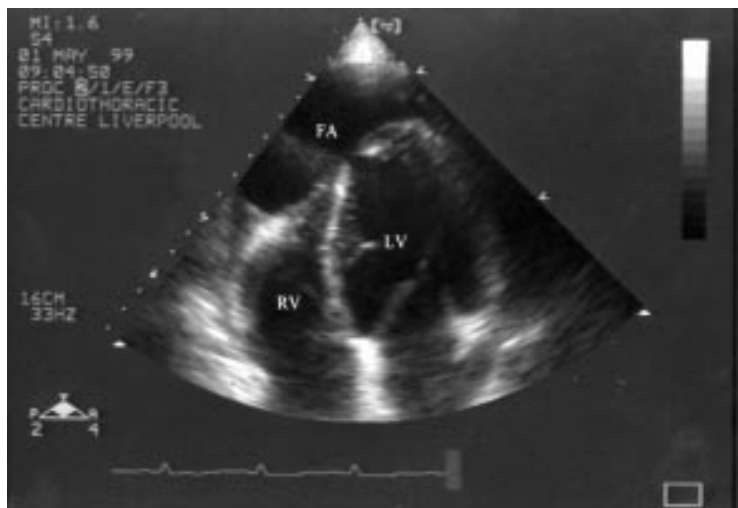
Apical four chamber view showing the point of free wall rupture. FA, false aneurysm.
